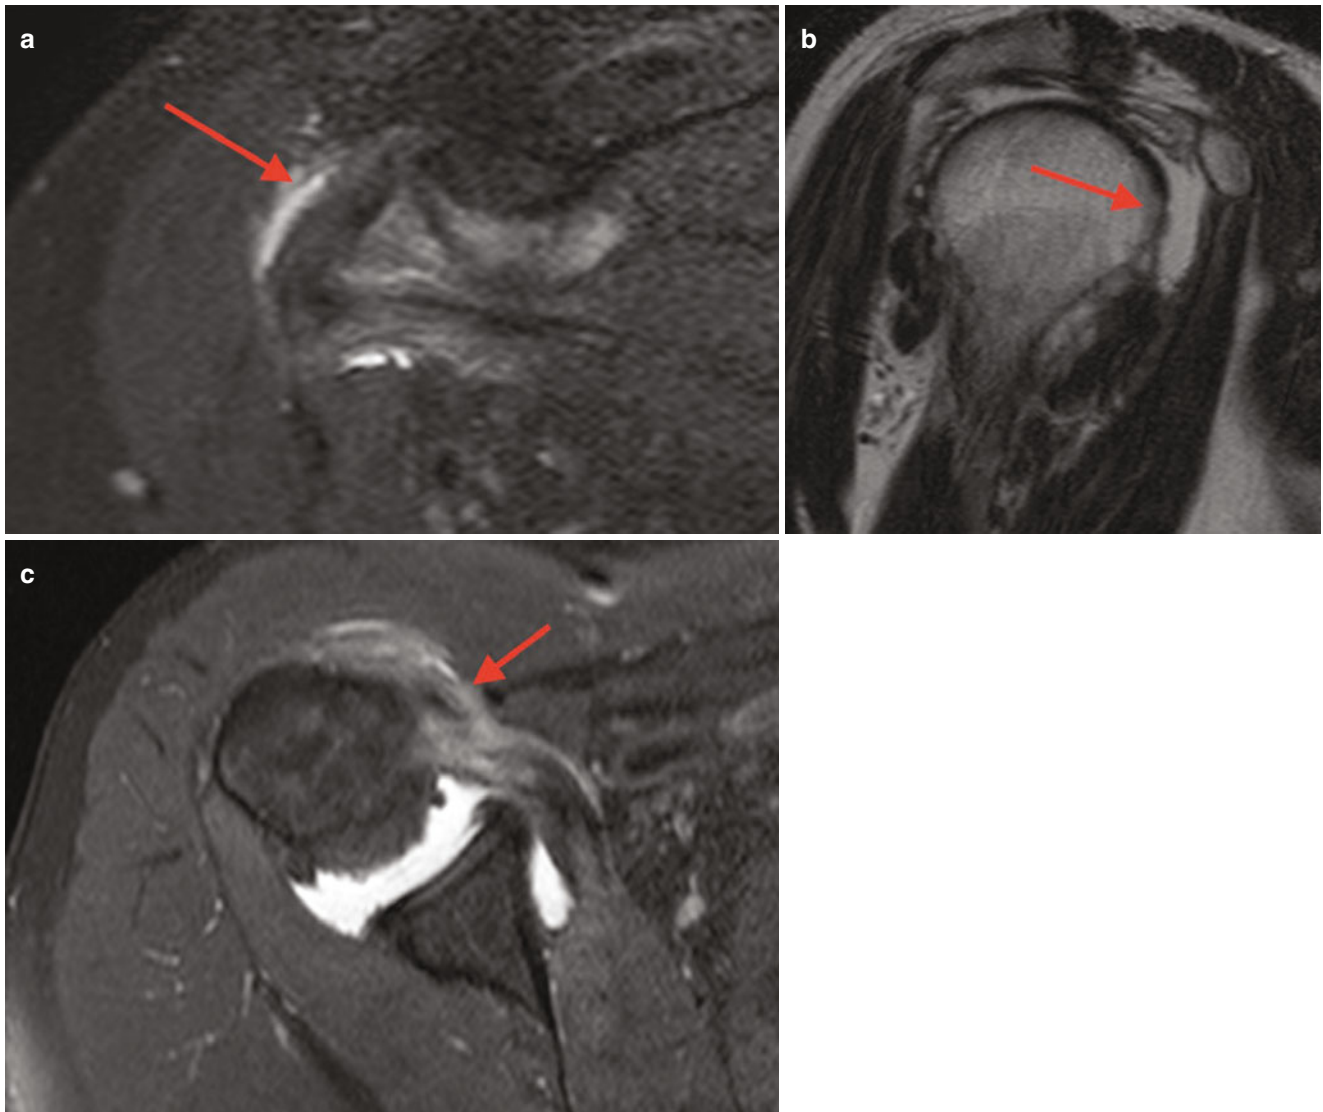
MRI showing complete lesion of the subscapularis tendon with medial dislocation of the long head biceps tendon (LHBT) (*red arrow*); (a) coronal view; (b) sagittal view; (c) axial view
